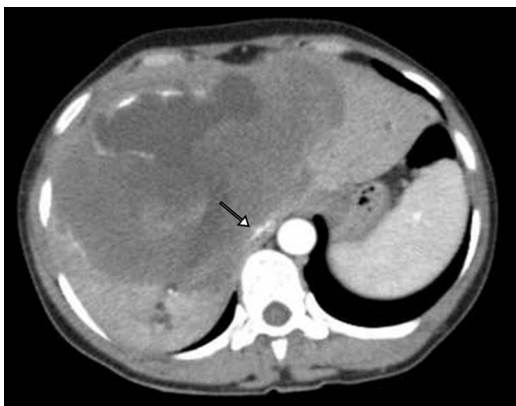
CT view of liver. Compressed IVC is seen with arrow.
